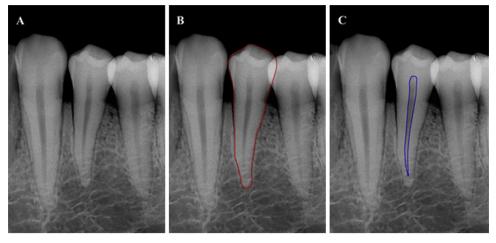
Radiographic image of left lower premolar (34), after processing and measuring pulp and tooth areas with line tool: red line, tooth area; blue line, pulp area.
